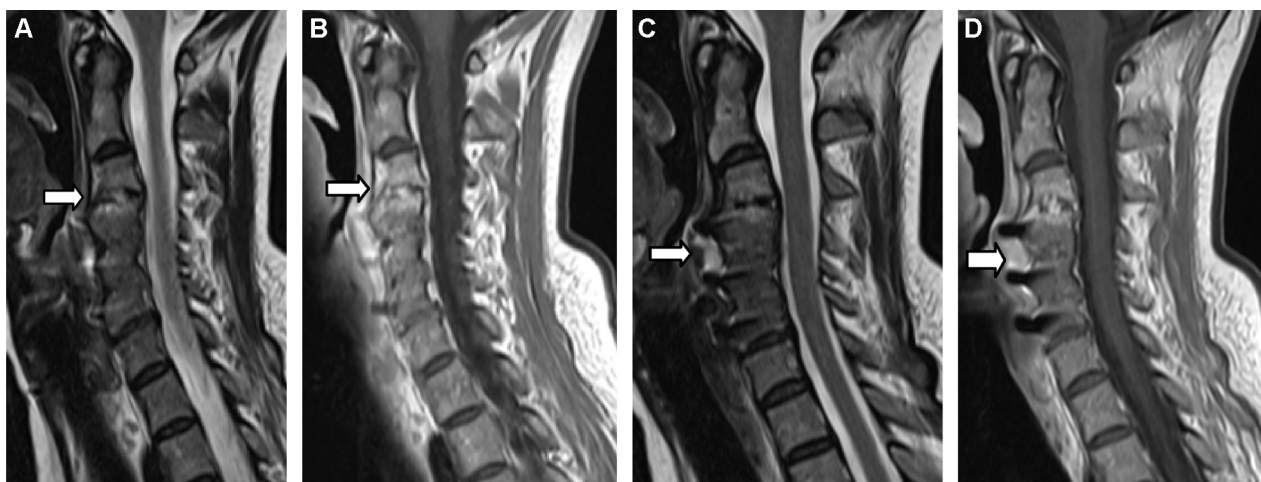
A–D. MRI examination two years after spondylodesis C4–C6. T2 weighted sequences in the sagittal plane (1A) show signal intensities in the interdiscal space C3/C4 with (1B) contrast enhancement in T1 weighted sequences with gadolinium. T2 weighted sequences in the sagittal plane (1C) show signal intensities prevertebral at the height of C4 with (1D) contrast enhancement in T1 weighted sequences with gadolinium, suggesting highly spondylodiscitis with a prevertebral abscess.
